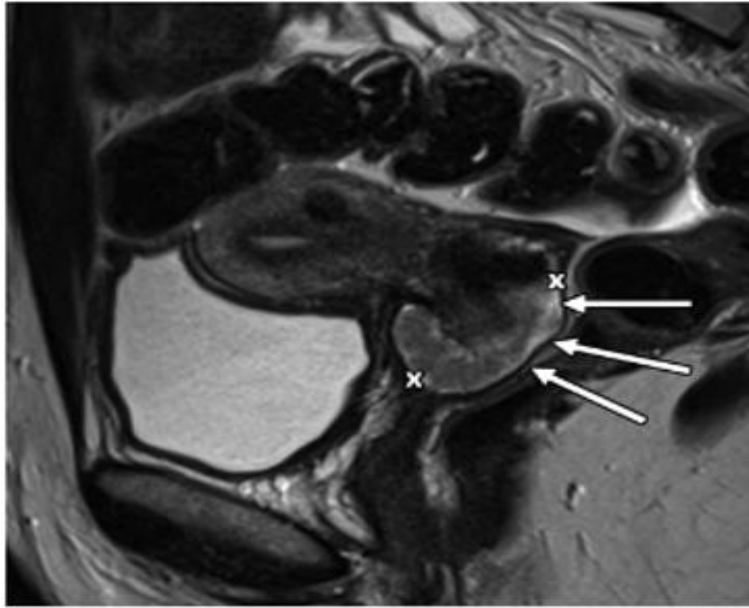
2018 FIGO stage IB1 disease in a 23-year-old woman with an abnormal cervical smear at screening. (a) Sagittal T2-weighted MR image shows a 1.4-cm tumor with intermediate T2-weighted signal intensity (calipers) centered on the anterior cervix. (b, c) Axial diffusion-weighted image (b) and apparent diffusion coefficient (ADC) map (c) show the tumor (arrowhead) more conspicuously with restricted diffusion. With no disease outside the cervix, these imaging findings are consistent with 2018 FIGO stage IB1 (unchanged from the 2009 FIGO classification). Given the tumor size and location, this patient would be suitable for fertility-sparing surgery (trachelectomy).
